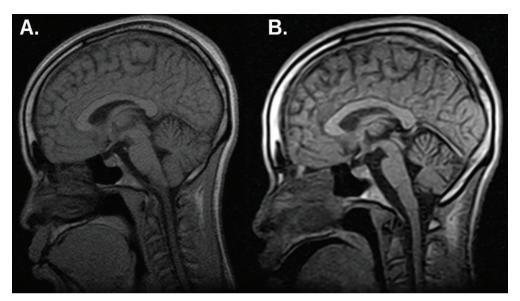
Brain Magnetic Resonance Imaging of Patient IV-4 Shows Progressive Cerebellar Degeneration and Atrophy of the Medulla, Pons, and Brainstem. (A) Nine years after symptom onset. (B) Fourteen years after symptom onset.
